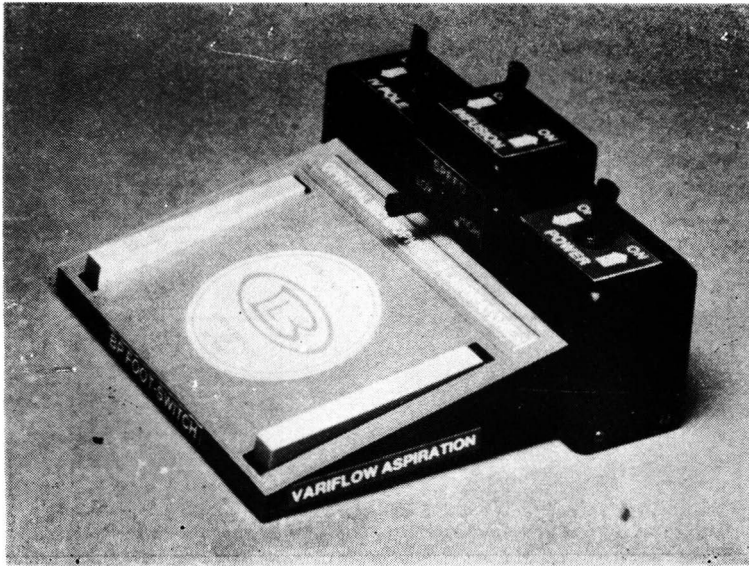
Picture of the multi-purpose foot-switch showing the parallel right and left two-step pedals and the central switch, which not only changes the speed of the vitreous cutter but also regulates the ultrasonic vibrations of the phacoemulsificator. The upper part of the foot-switch contains three additional switches: 1) The connection to the power for either the vitrectomy or phacoemulsifier instruments, 2) Power connection to the infusion line, and 3) Height control for the motorized infusion pole.
